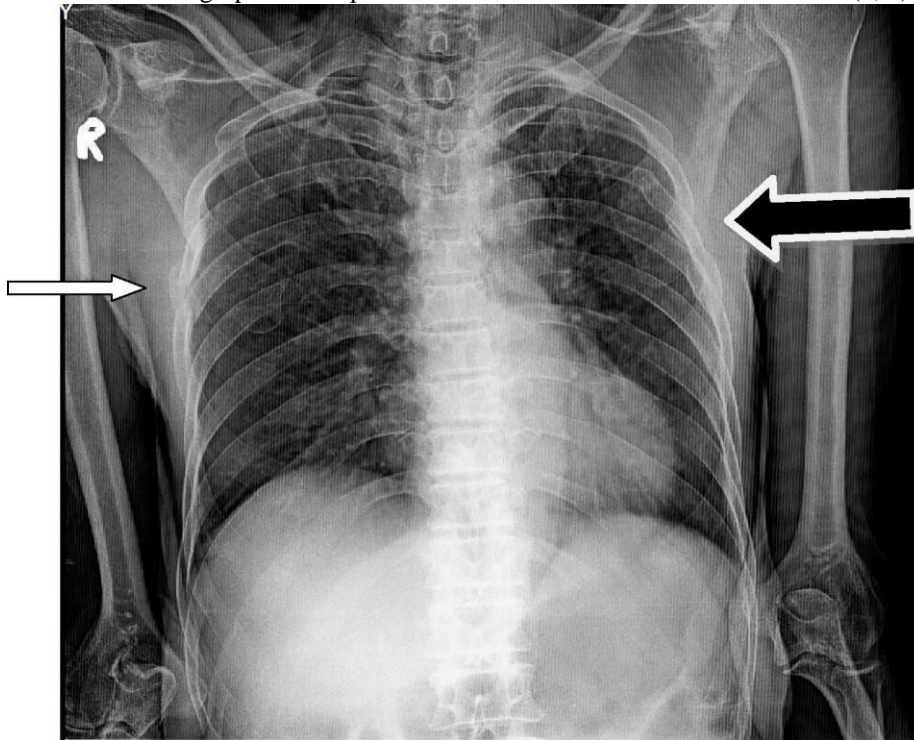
Rib fractures. Frontal radiograph of the chest shows acute fracture on the right side of the rib cage (white arrow mark) and old healed fractures on the left side (black arrow mark)
